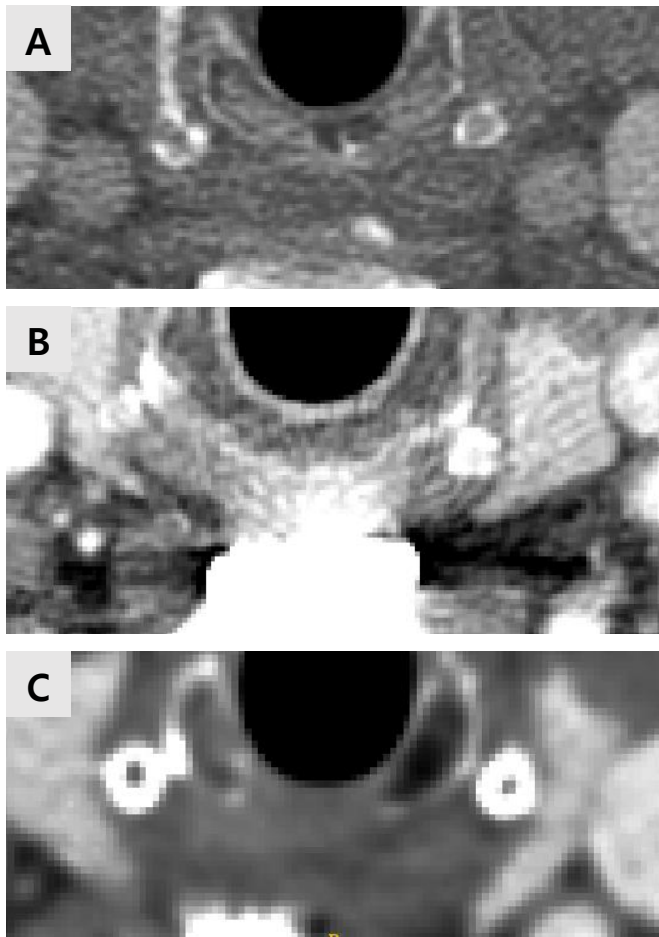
Representative examples of unevaluable CT findings.
